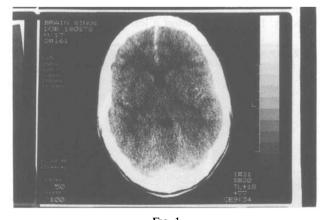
Initial CT scan for *Case 1* fails to demonstrate any intracranial abnormality.
